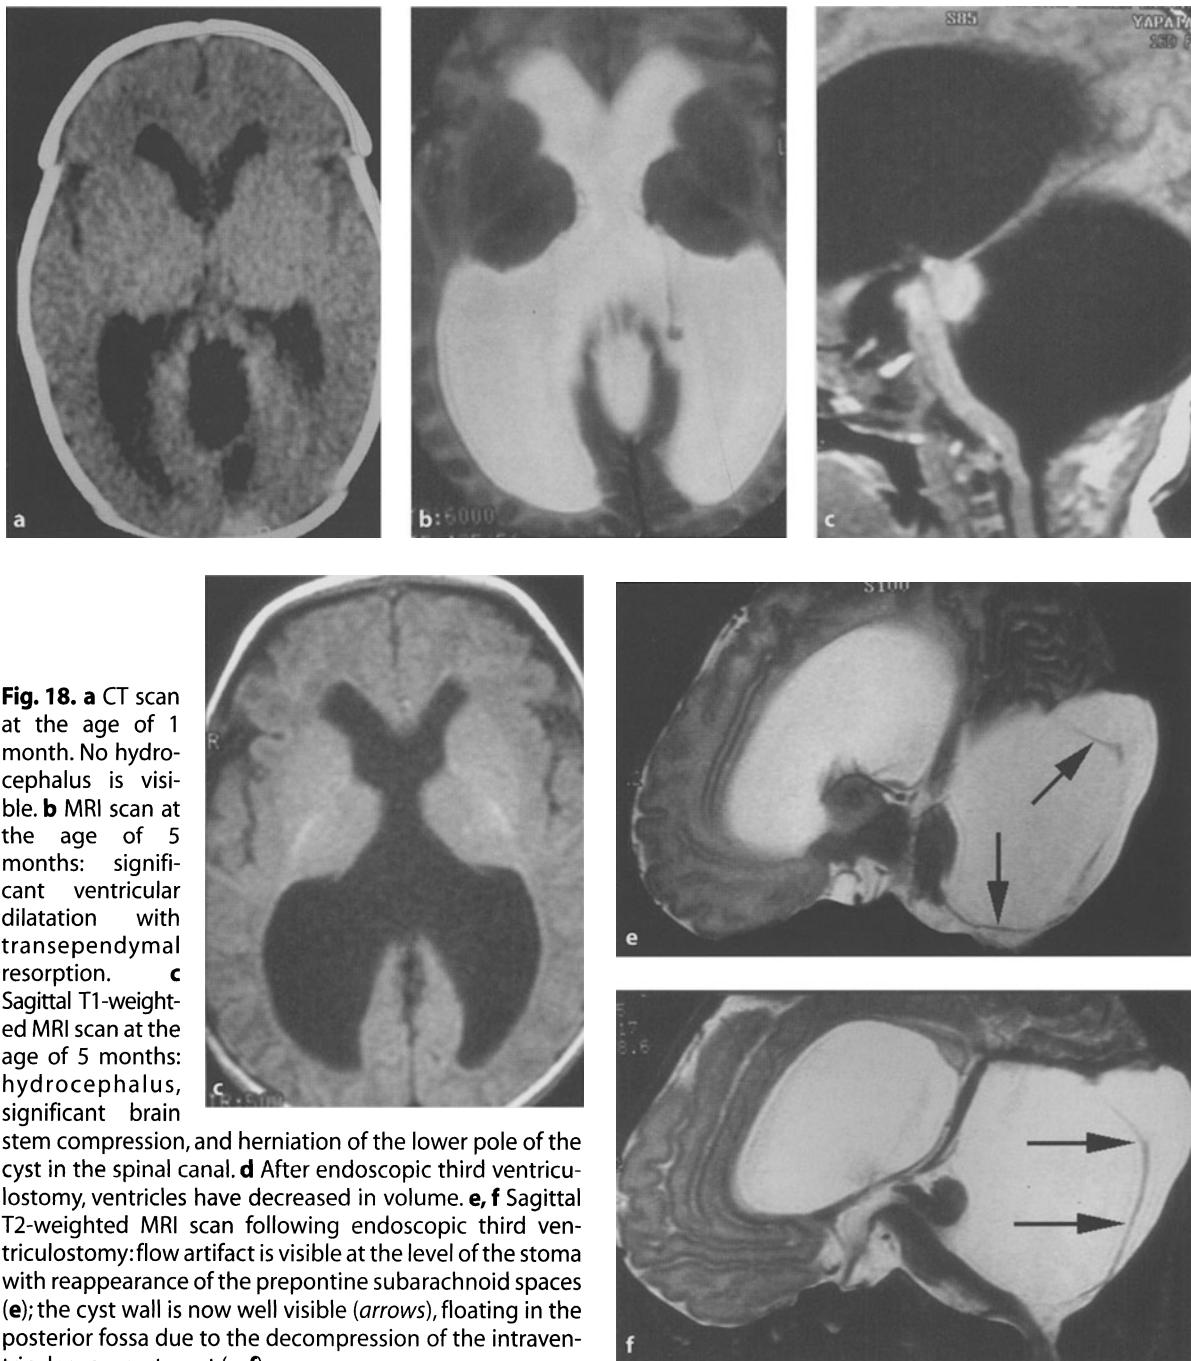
a CT scan at the age of 1 month. No hydrocephalus is visible. b MRI scan at the age of 5 months: significant ventricular dilatation with transependymal resorption. c Sagittal T1-weighted MRI scan at the age of 5 months: hydrocephalus, significant brain stem compression, and herniation of the lower pole of the cyst in the spinal canal. d After endoscopic third ventriculostomy, ventricles have decreased in volume. e, f Sagittal T2-weighted MRI scan following endoscopic third ventriculostomy: flow artifact is visible at the level of the stoma with reappearance of the preopticine subarachnoid spaces (e); the cyst wall is now well visible (arrows), floating in the posterior fossa due to the decompression of the intraventricular compartment (e, f)
